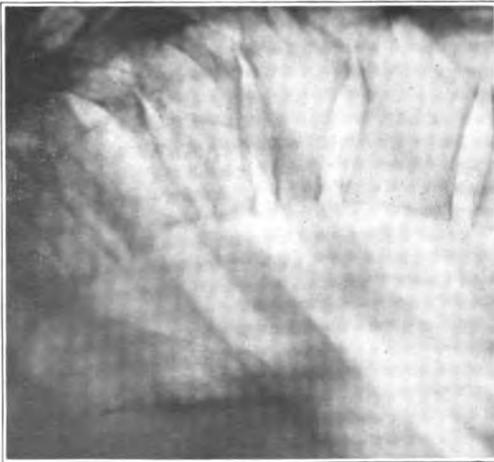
X-ray of epileptic, Case No. 99. Major fractures—D6, 8, 9. Minor fracture—D7.
